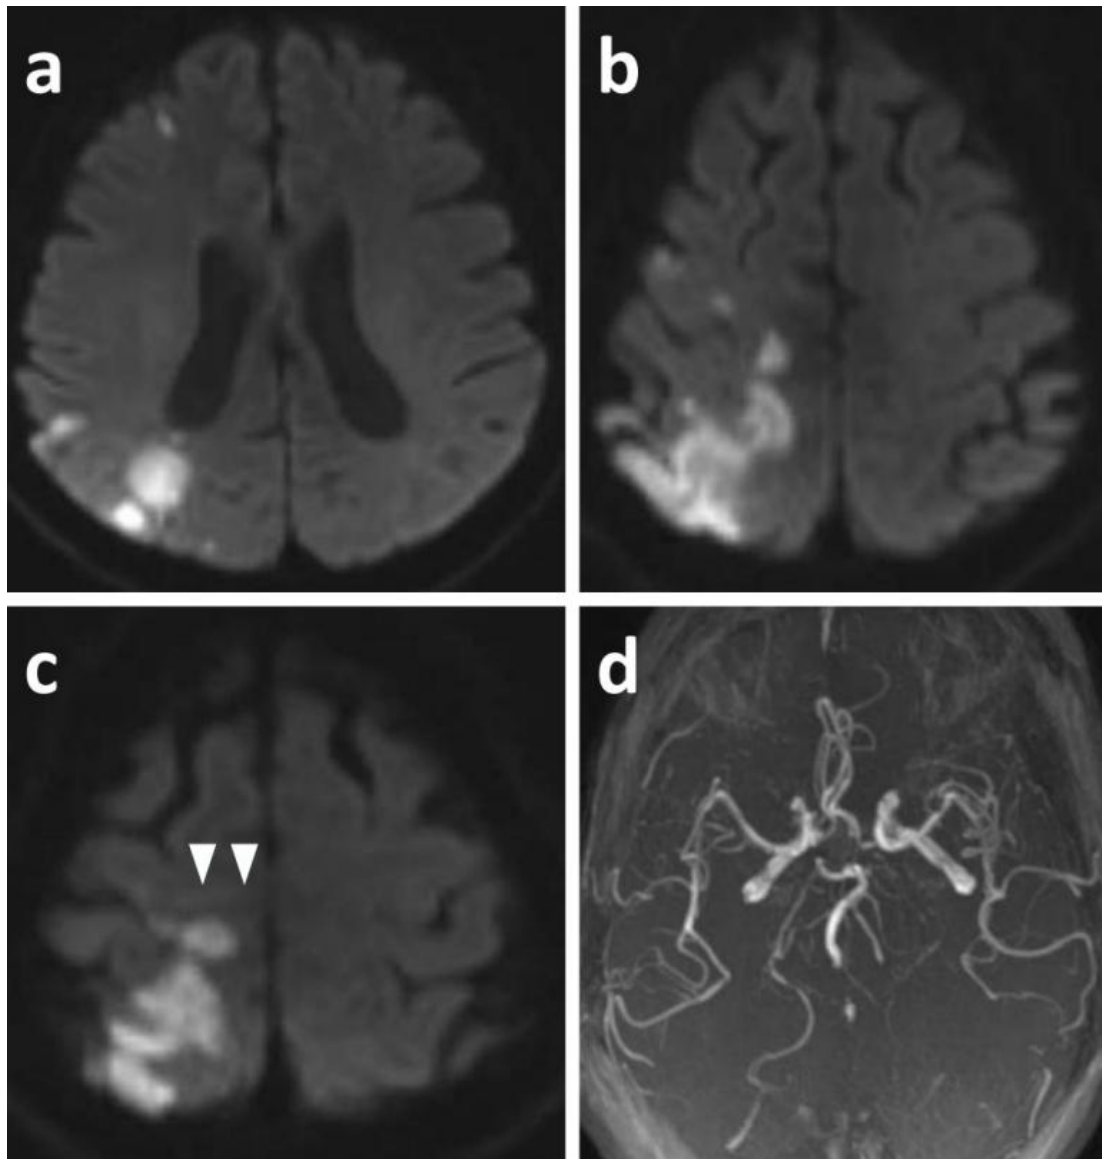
MRI Brain DWI axial images (a-c) show acute infarction in the right frontoparietal region including involvement of trunk area in right parasagittal premotor cortex (c, arrowheads). MRA brain (d) showed mild atheromatous narrowing of all intracranial arteries with moderate stenosis of left PCA.
